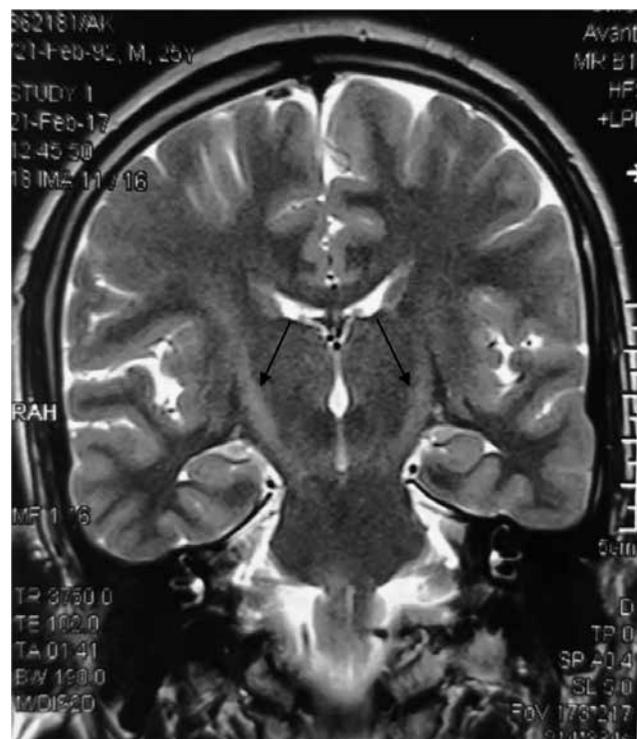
MRI brain coronal section showing bilaterally symmetrical hyperintensities involving the corticospinal tracts giving a 'wine glass' appearance.
